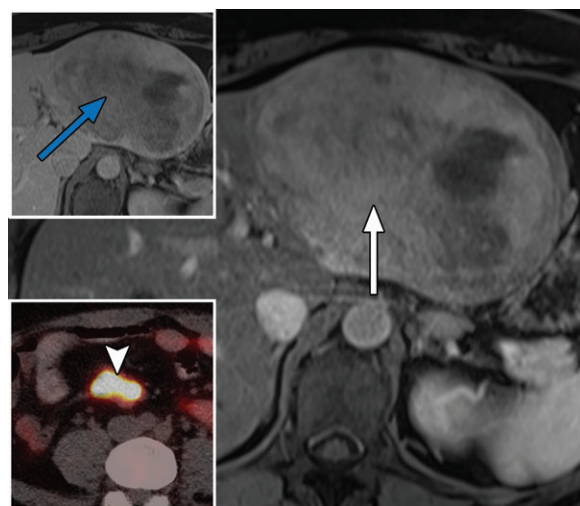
Washout of a liver mass in a 38-year-old woman with metastatic neuroendocrine carcinoma. Axial T1-weighted arterial phase MR image shows nonrim hyperenhancement of a large mass (white arrow) in the left lateral section of the liver, which subsequently washes out (blue arrow) on the portal venous phase image (top inset). Washout is not specific for HCC in patients without cirrhosis or other risk factors. In this patient, the mass represents a metastasis from metastatic neuroendocrine carcinoma, with a mesenteric mass (arrowhead) identified on the gallium 68 (^{68}Ga)-[tetraxetan-D-Phe1, Tyr3]-octreotate (DOTATATE) PET/CT image (bottom inset).
